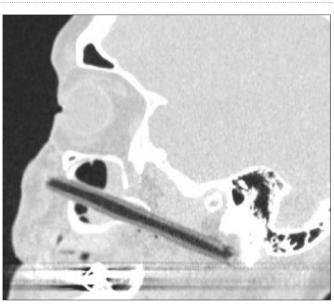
c: Oblique sagittal reconstruction of the unenhanced CT scan displayed on bone windows, again showing the location of the cane.
